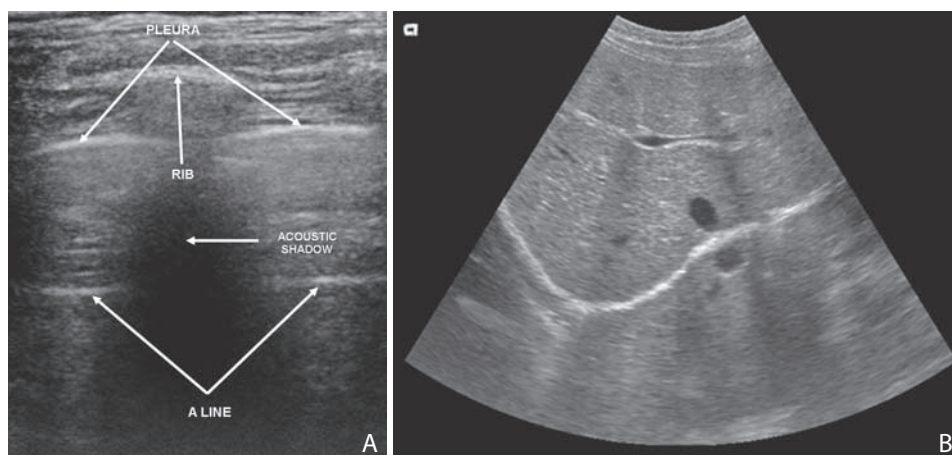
Normal lung ultrasonographic finding using the trans-thoracic approach in longitudinal section (A), and using the trans-hepatic approach – “mirror image” phenomenon (B).
